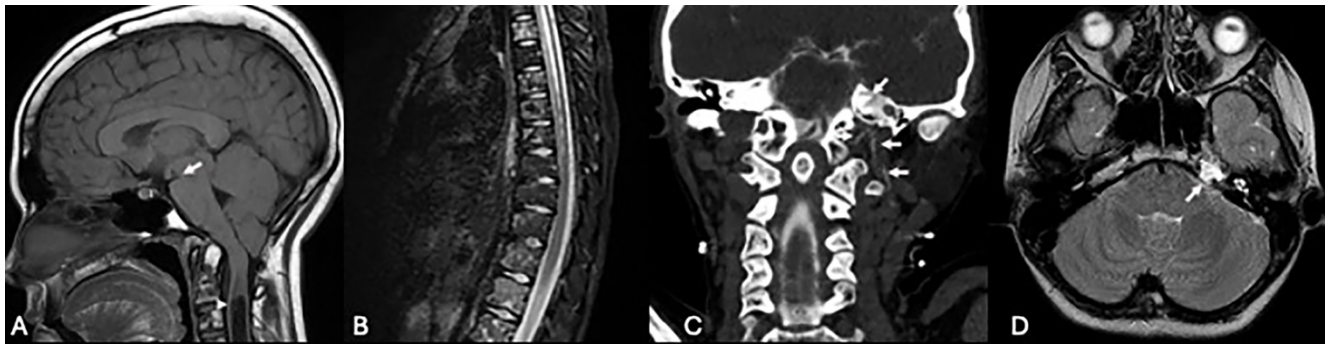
Patient 4: Skull base CSF-lymphatic malformation fistula in a 13-year-old female who had a history of generalized lymphatic anomaly for multiple years who presented with more recent onset of headaches. *A*, Sagittal T1-weighted image of the brain shows mid brain sag (arrow), along with cerebellar tonsillar descent and a syrinx (arrowhead). *B*, Sagittal short tau inversion recovery image of the thoracic spine shows diffuse intraosseous lymphatic malformations. Bilateral decubitus CT myelograms did not show a CSF fistula (not shown), but a CT cisternogram of the skull base (*C*) showed frank leakage from the left petrous apex into the left neck musculature (arrows) that extended to the C3 level. *D*, Axial T2-weighted image shows a left petrous apex lymphatic malformation (arrow) that was observed in retrospect.
